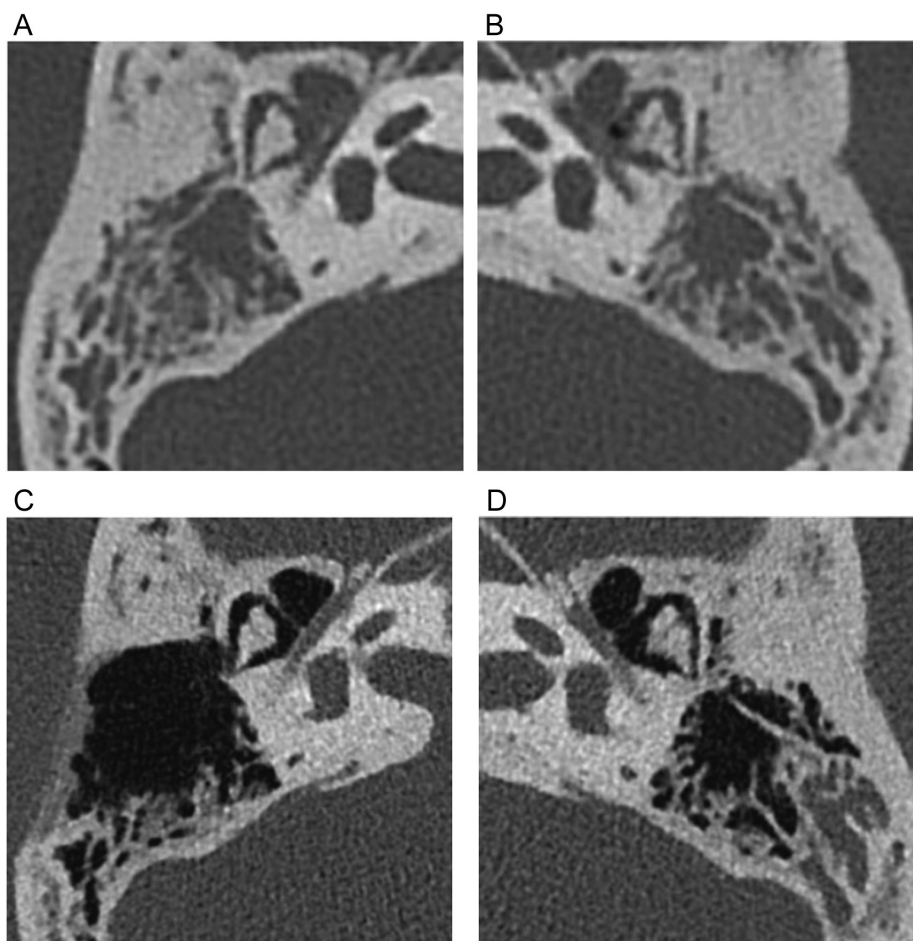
Computed tomography findings. A, B) At the initial visit, the tympanum and mastoid air cells were filled with soft tissue attenuation in both (A: right, B: left) ears. No apparent bone destruction was observed. C, D) After the treatment, air was observed in the tympanum and mastoid air cells of both (C: right, D: left) ears.
